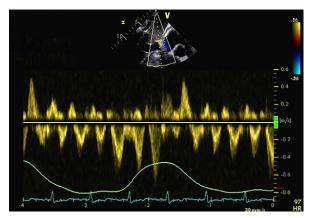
Pulsed-wave echocardiogram with color-flow Doppler shows diastolic flow reversal in the hepatic veins.
